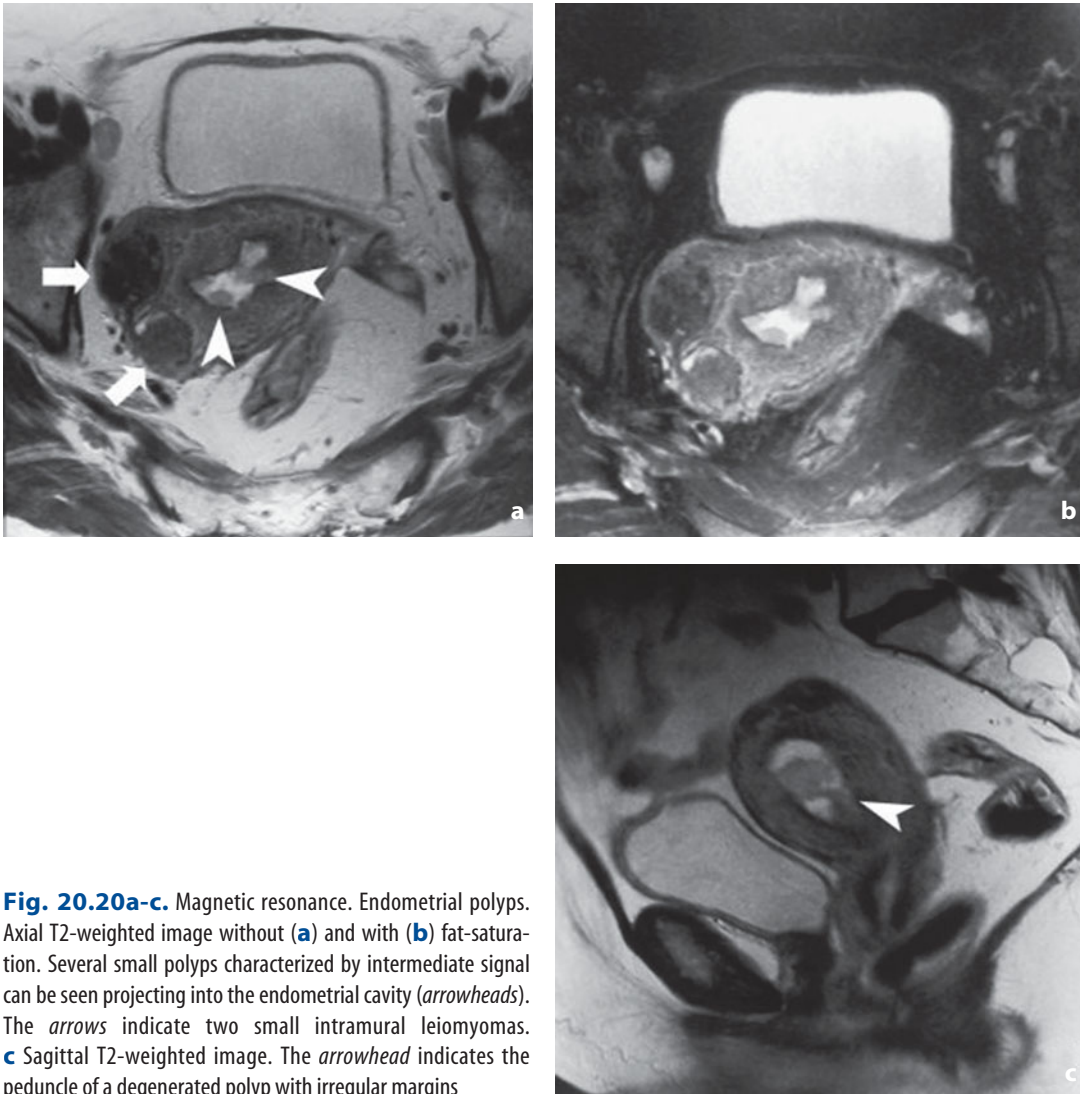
Magnetic resonance. Endometrial polyps. Axial T2-weighted image without (a) and with (b) fat-saturation. Several small polyps characterized by intermediate signal can be seen projecting into the endometrial cavity (*arrowheads*). The *arrows* indicate two small intramural leiomyomas. c Sagittal T2-weighted image. The *arrowhead* indicates the peduncle of a degenerated polyp with irregular margins
